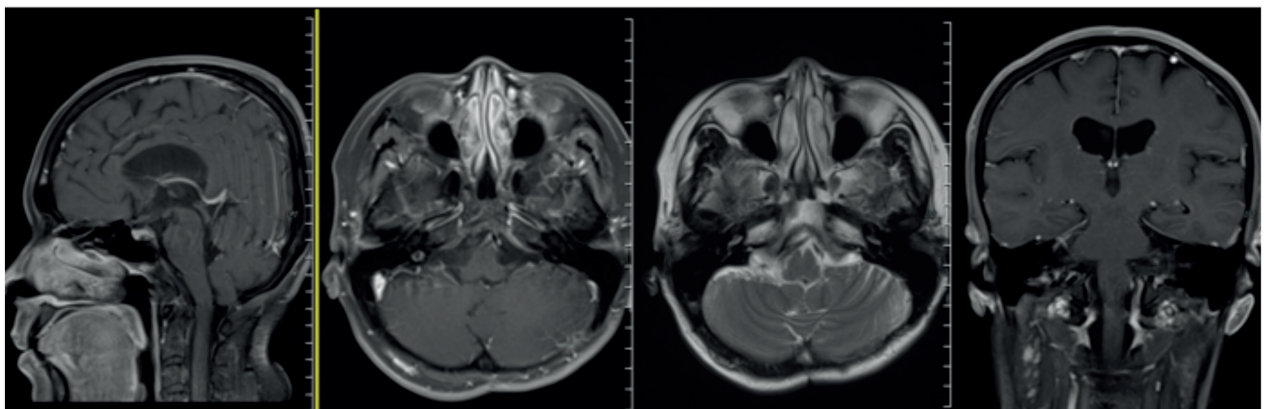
Magnetic resonance imaging (MRI) scan revealing post-tumor removal without abnormal enhancing lesions at the preponine cistern, premedulla oblongata, and posterior of the clivus.
